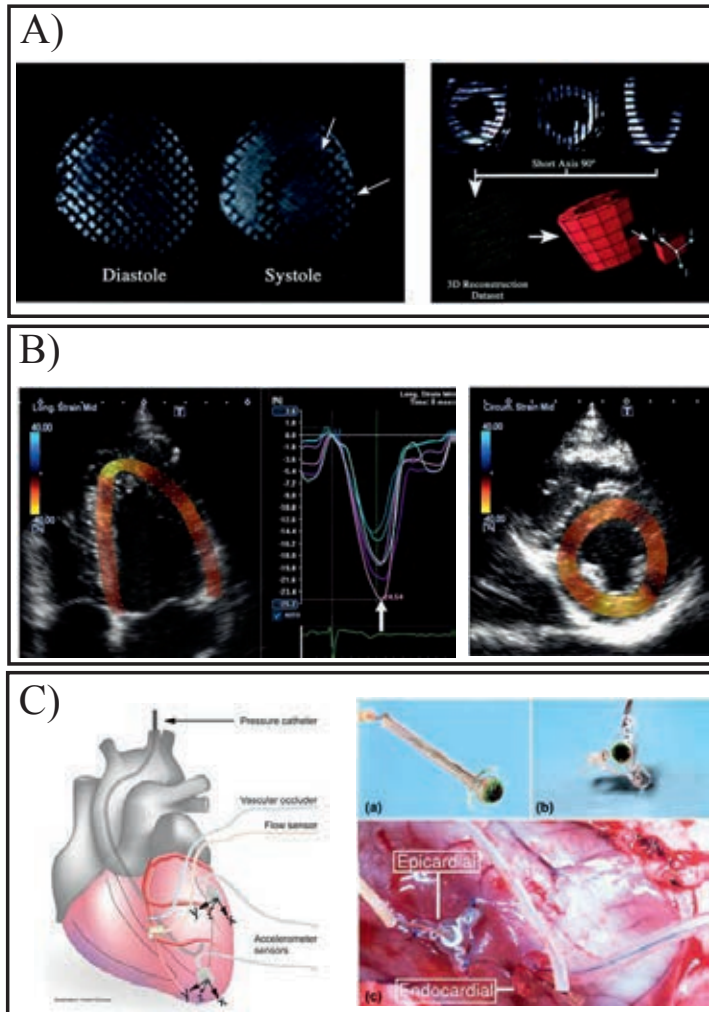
Figure A shows cardiac wall motion tracking using tagged MRI, Figure B indicates Speckle tracking for longitudinal wall motion tracing in echocardiography/TDI, Figure C shows implanted MEMS accelerometer and gyroscope sensors for measuring myocardial linear and angular movements (From: [37–40] © Reprint with permission).
